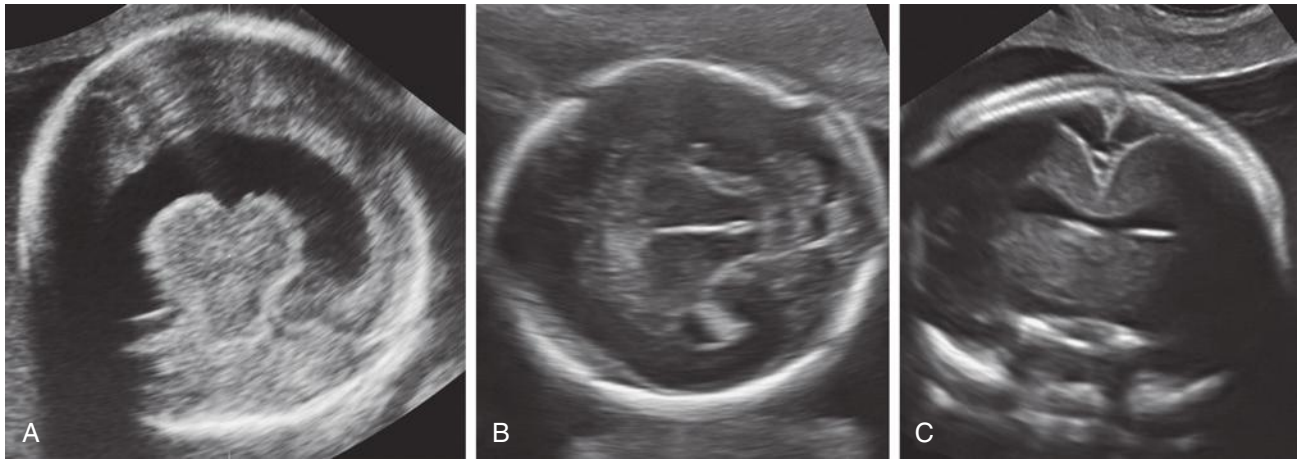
Holoprosencephaly. A, Alobar holoprosencephaly with a large single ventricular cavity (monovertricle) and fused thalami; B, milder case with subtle findings—the anterior midline structures are absent. The single ventricular cavity and absent septum were best demonstrated by means of transvaginal sonographic image in the coronal plane (C).
